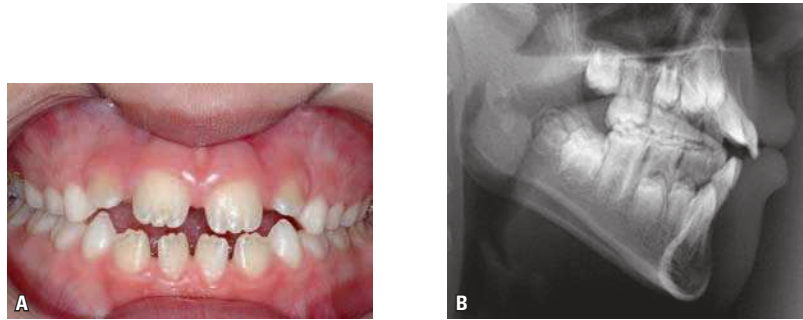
AOB caused by poor posture of the tongue at rest and lip interposition (A). Cephalometric radiograph contrast allows the tongue to be viewed in its resting position, supported by the mandibular incisors, preventing their proper eruption, and the interposition of the lower lip between the incisors, preventing the proper eruption of the maxillary incisors is also visible (B).
